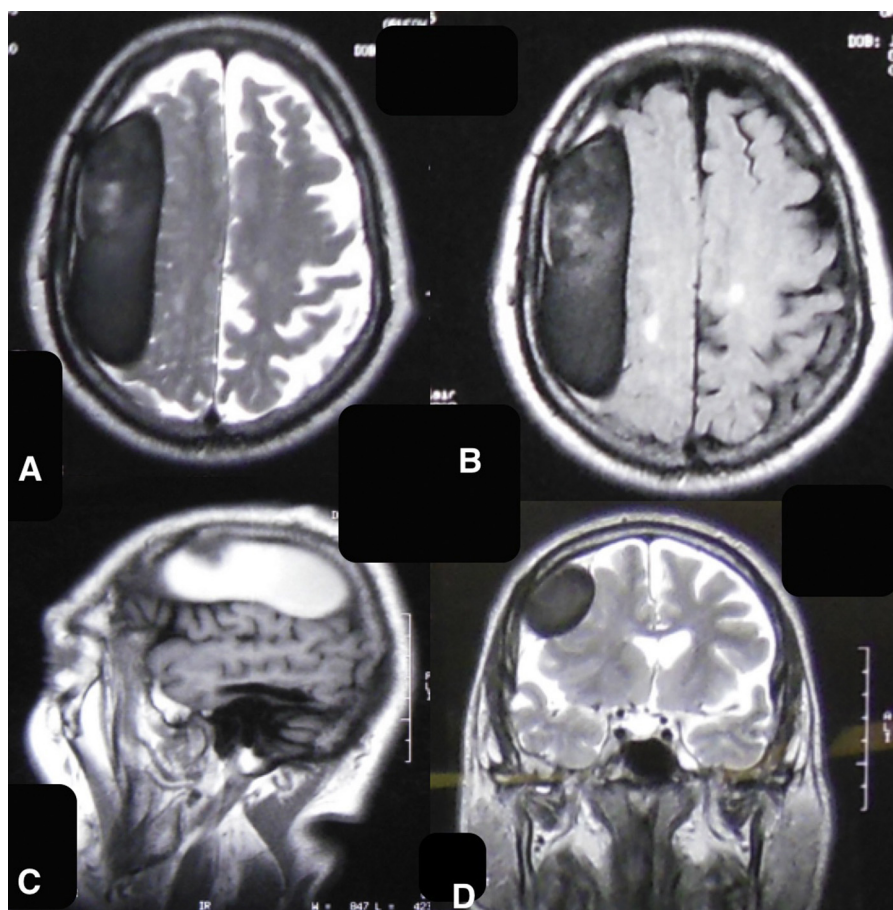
A sausage-like mass is observed over right cerebral hemisphere. It is hypointense on T2- and FLAIR-weighted (A, B and D), hyperintense on T1-weighted MR images (C).
